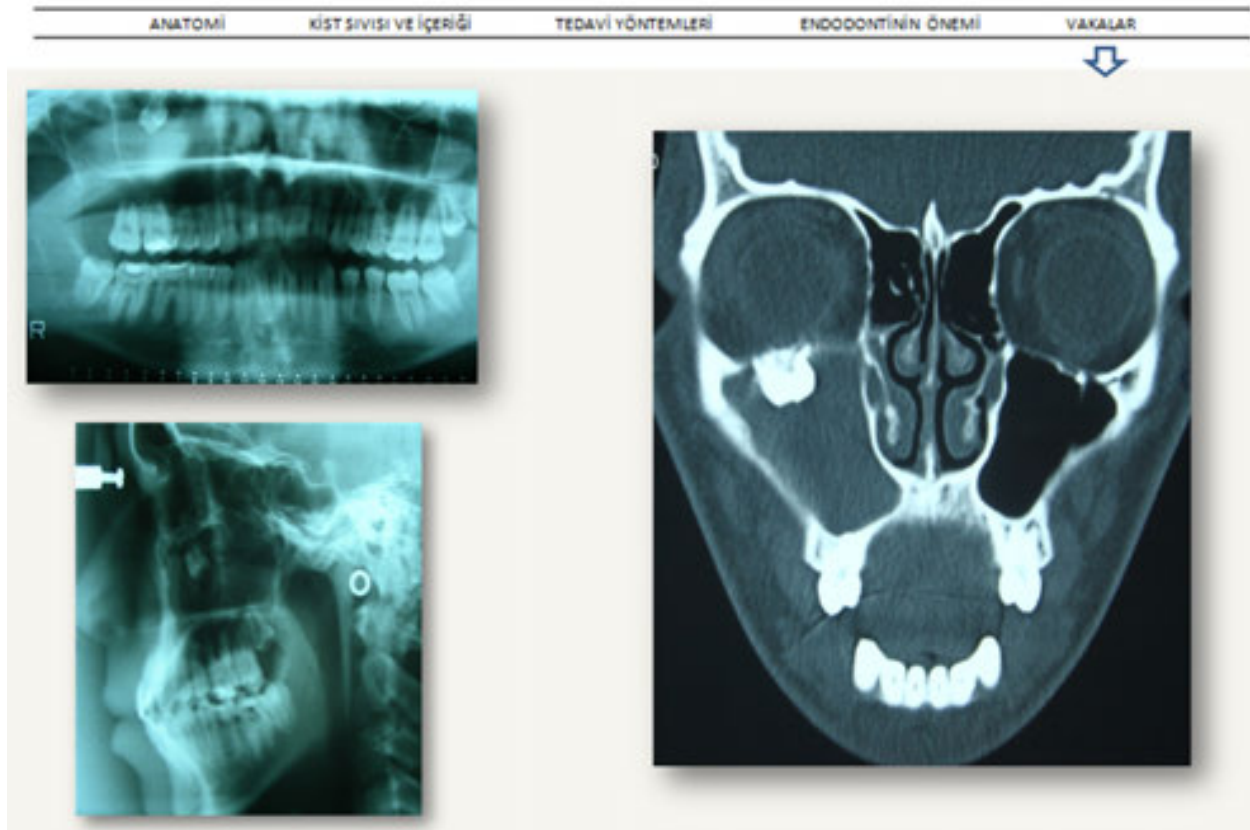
Panoramic radiograph, lateral cephalometric and CT views showing tooth in the right maxillary sinus.
